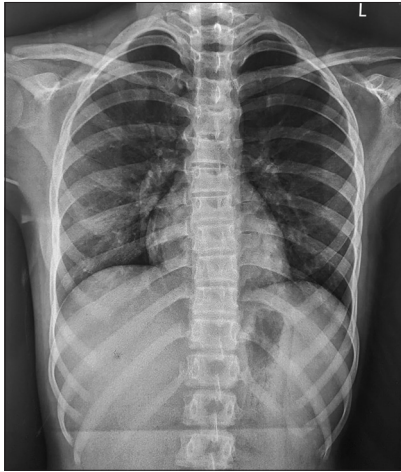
Chest X-ray revealing normal chest shape with no visible deformities
